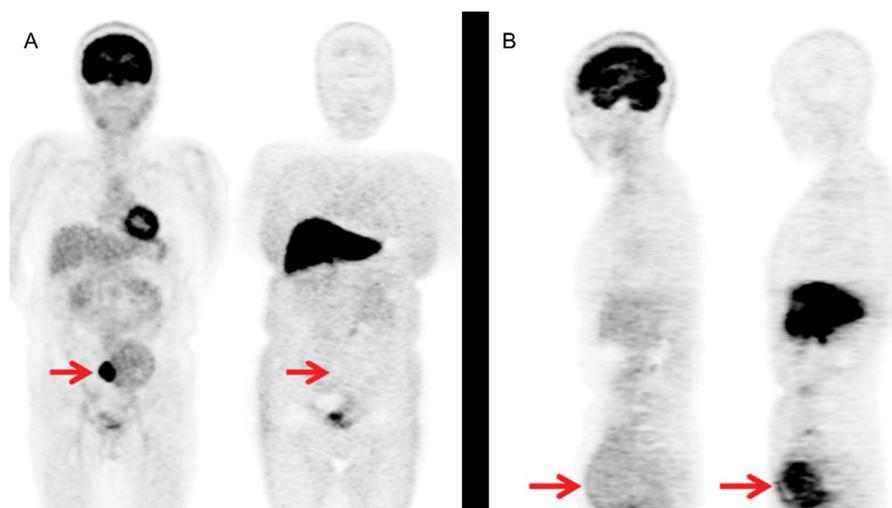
(A) Leiomyosarcoma. Body FDG-PET (left) and FES-PET (right) images of a 56-year-old woman with uterine leiomyosarcoma (red arrows). The SUV for FDG and FES, and FDG/FES ratio were 12.0, 0.9, and 13.3, respectively. Low uptake of FES significantly correlated with low expression of ER α (not shown). (B) Leiomyoma. Body FDG-PET (left) and FES-PET (right) images of a 49-year-old woman with uterine leiomyoma (red arrows). The SUV for FDG and FES, and FDG/FES ratio were 1.9, 6.2, and 0.3, respectively. High uptake of FES correlated with high expression of ER α (not shown). Reprinted with permission.¹⁷
